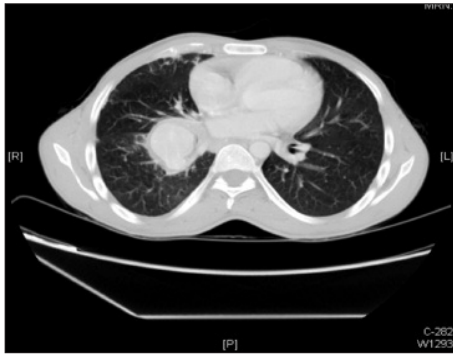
CT Chest showing large aneurysm in inferior branch of the right pulmonary artery. It has relatively thick irregular wall and measures about 4.0 x 3.5 cm.
